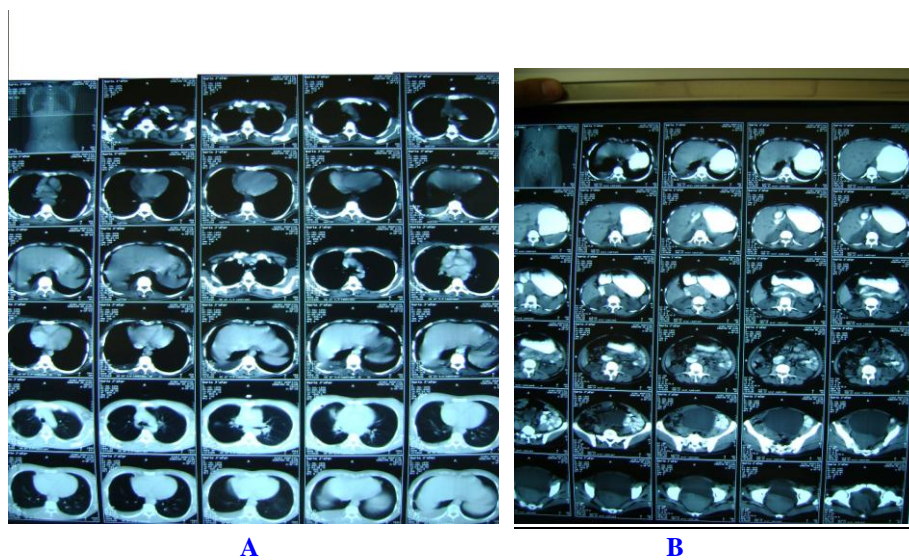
Postoperative CT-scan of the chest (A), and abdomen (B)
